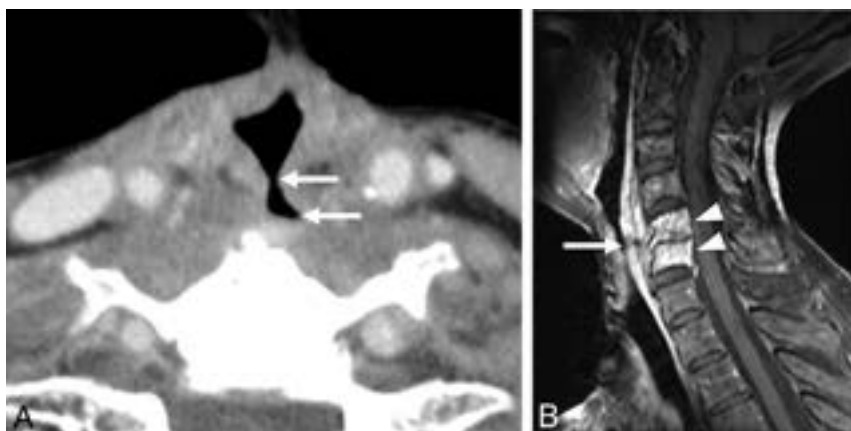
A 74-year-old woman with a history of laryngeal carcinoma, status post total laryngectomy and radiation, and recent esophageal dilation presented with neck pain and fever. A, An axial postcontrast CT image demonstrates a sinus tract extending to the vertebral body (arrows). B, Sagittal T1 postcontrast fat-saturated MR image demonstrates thickening of the prevertebral soft tissue with a focal defect (arrow) and enhancement of the C5 and C6 vertebral bodies (arrowheads) and loss of disk height with enhancement, consistent with diskitis/osteomyelitis.
